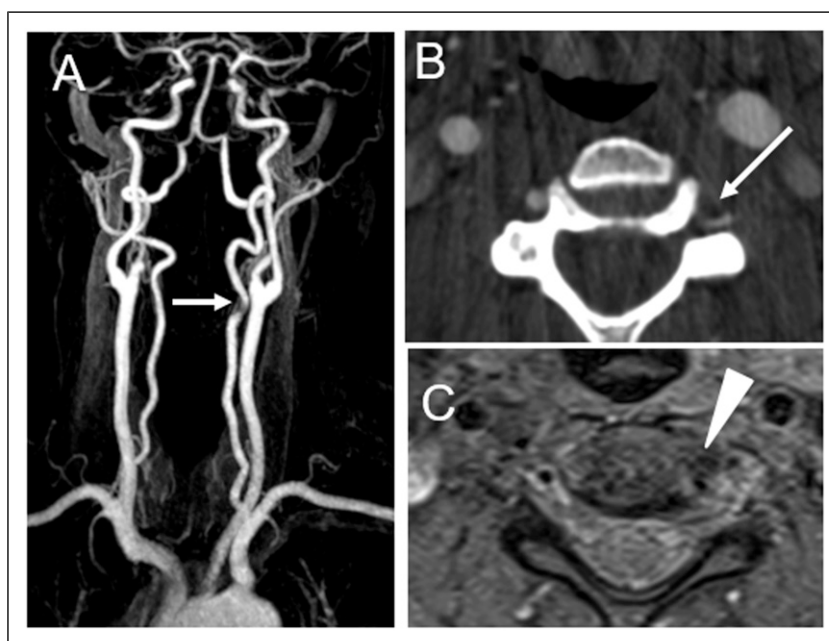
Case no. 3. Patient with acute left neck pain and left headaches, followed by paresthesias in the left C4 distribution, but no cerebral symptoms. (A, B) CTA showing compression and lateral displacement of the left vertebral artery on a C3-C4 level (white arrow). (C) Axial MRI T2W images showing a C3-C4 lateral disc herniation (white triangle) with loss of the VA lumen.
